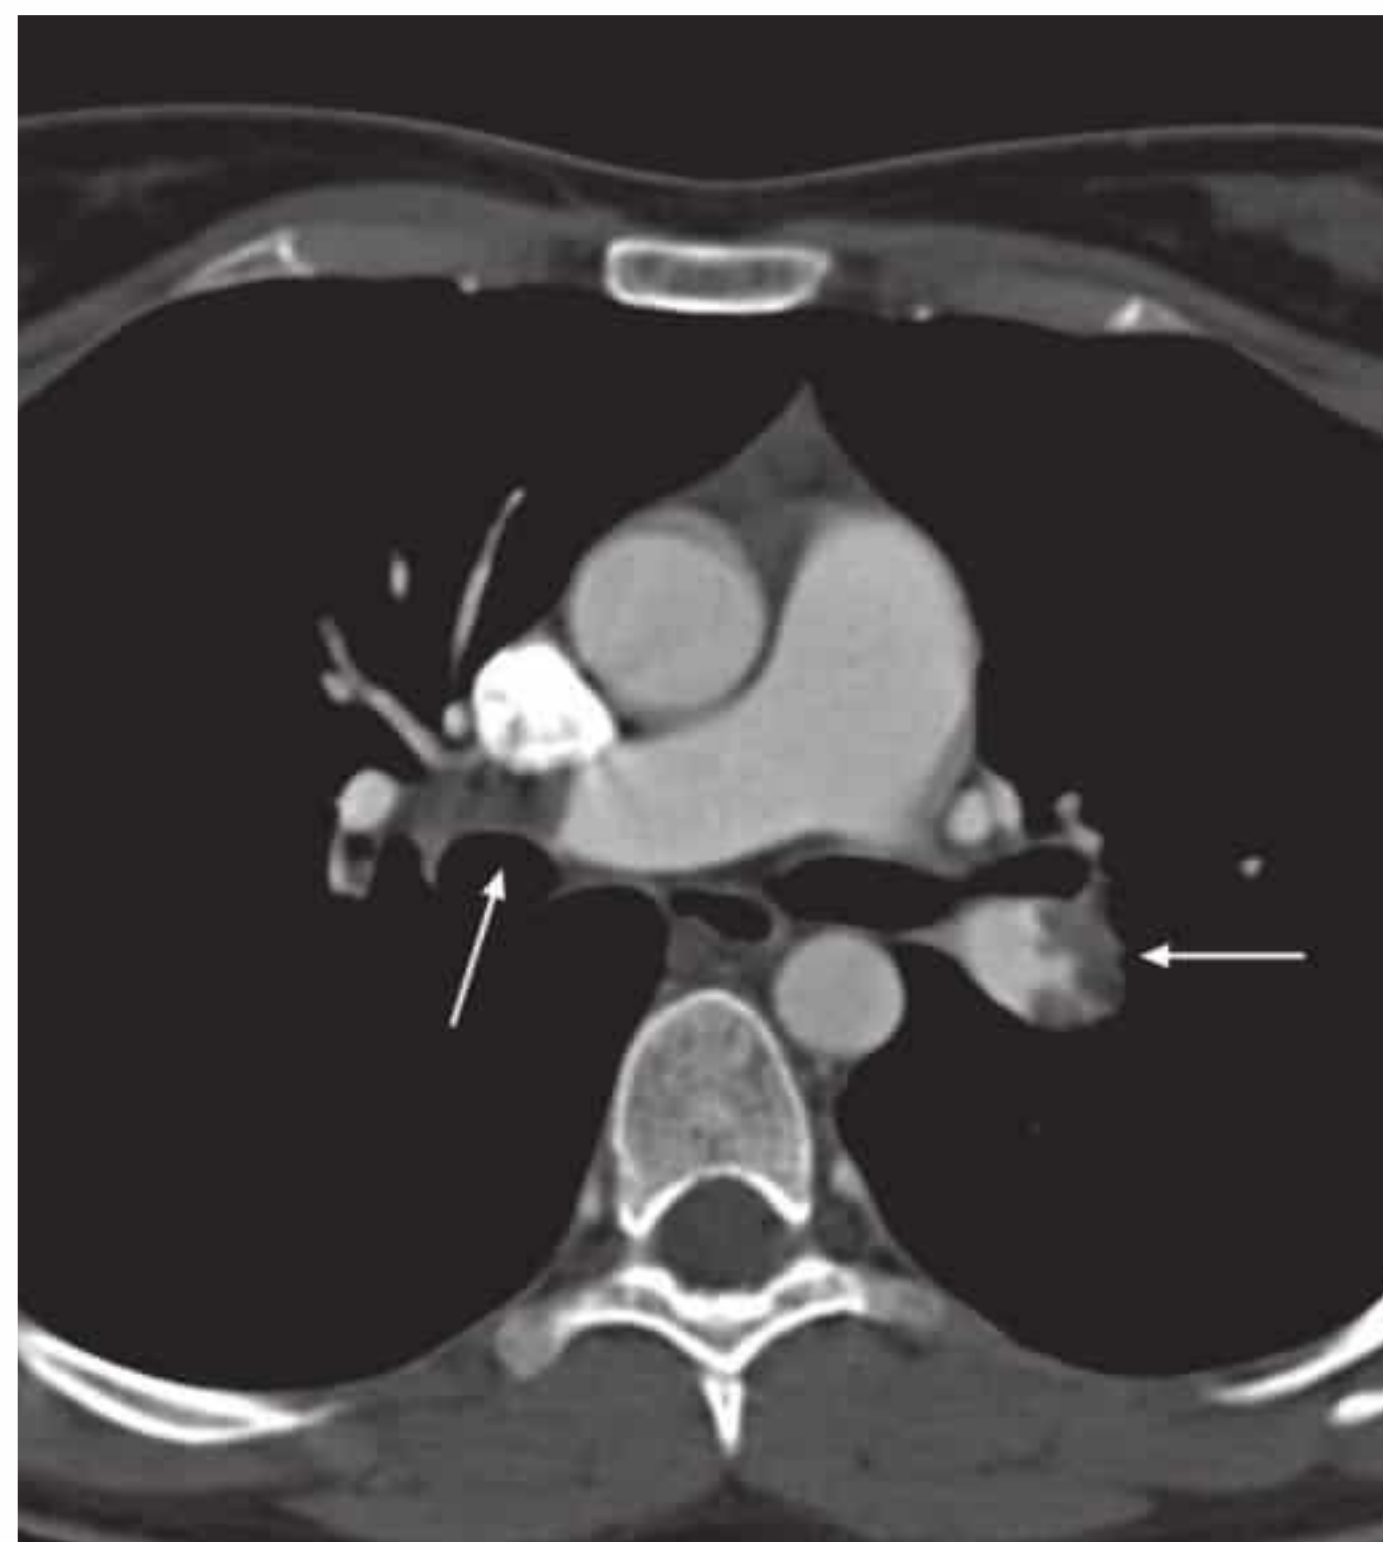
CT angiogram in acute pulmonary embolism demonstrates mural thrombi in the left lower lobe artery (arrow) and right central pulmonary artery (arrow).
